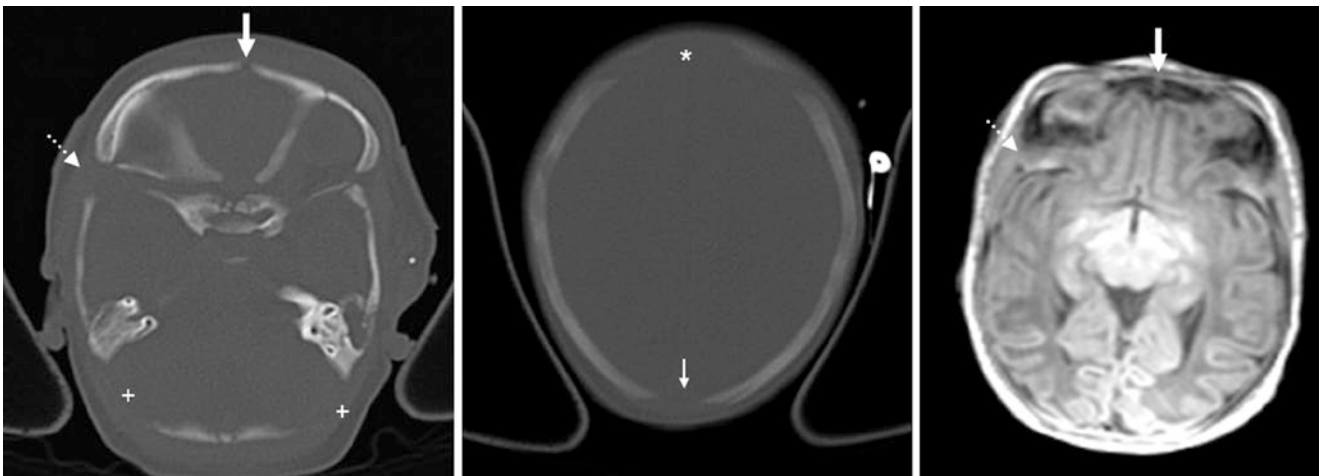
A 6 day old with patency of the AF (*), posterior fontanelle (thin arrow), mastoid fontanelle (+), sphenoid fontanelle (dotted arrows), and MS (arrows) on axial CT (left and middle) and on gradient-echo T1WI MRI (right)
